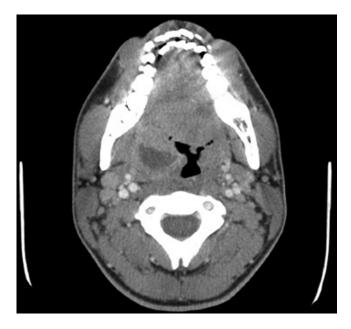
CT scan of a right peritonsillar abscess
